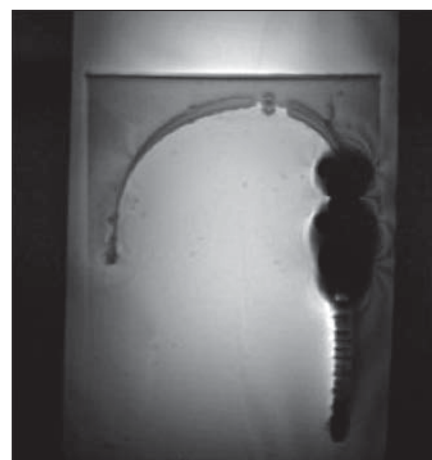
Gradient-echo MR image shows artifacts at 3 T for lead with receiver. Smaller artifact (i.e., signal loss) is seen at location of electrodes (left side, distal portion) and larger artifact at position of receiver (right side, proximal portion).
